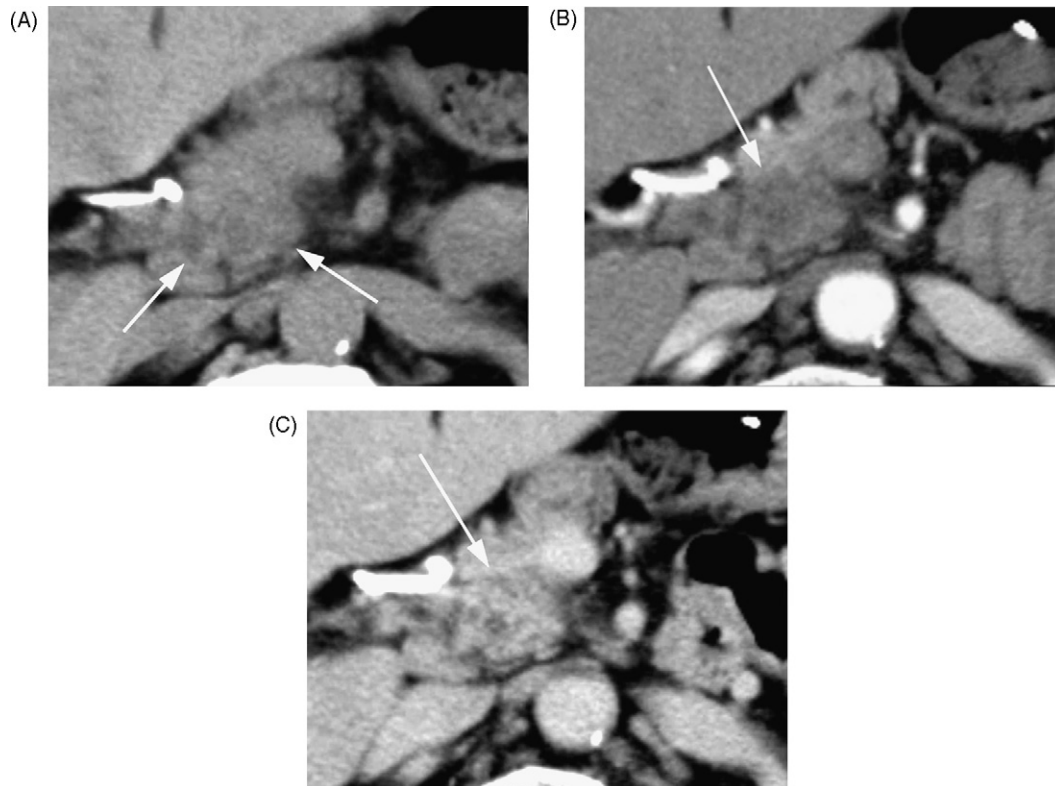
(A) Unenhanced CT shows a hypoattenuating mass lesion approximately 3.5 cm in diameter in the pancreatic head (arrows). (B) On arterial-dominant phase, the lesion does not show early enhancement relative to the surrounding pancreas (arrow). (C) Equilibrium-phase CT shows delayed enhancement of the lesion (arrow).
